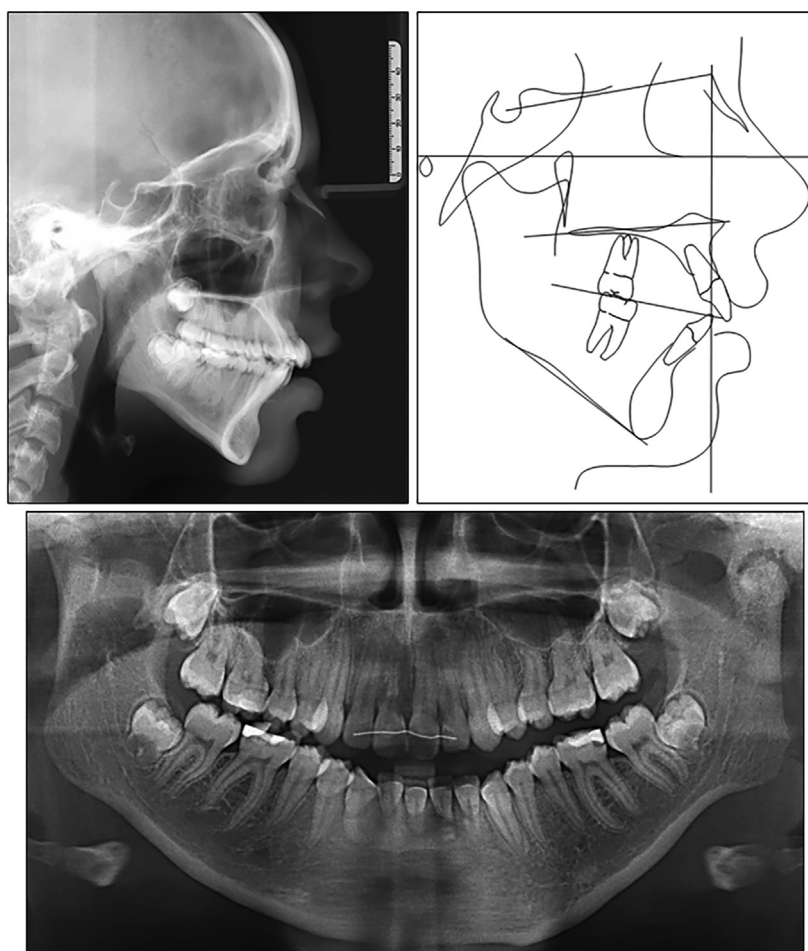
Initial panoramic radiograph, lateral cephalometric radiograph, and tracing.
